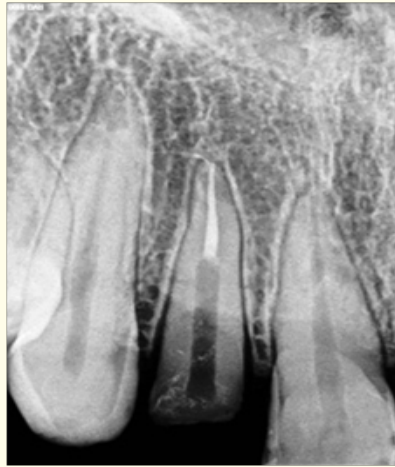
Post space radiograph.
